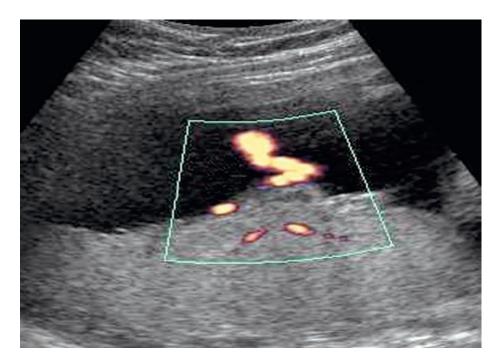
Power Doppler sonogram shows central cord insertion (arrow) in a posterior placenta (Romak, 2011)
